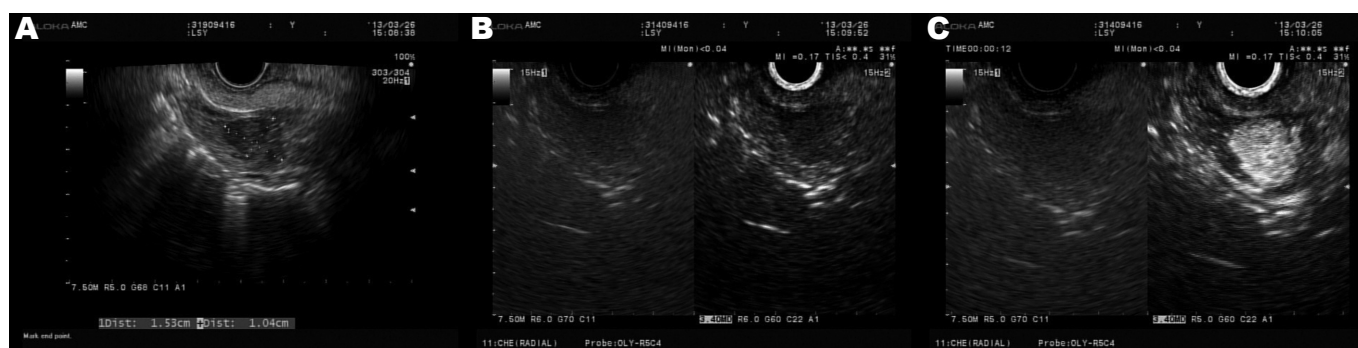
Neuroendocrine tumor. A: Hypoechoic pancreatic mass on conventional endoscopic ultrasonography; B: hypoechoic pancreatic mass on contrast-enhanced harmonic endoscopic ultrasonography (CH)-EUS (pre-contrast); C: homogeneously-enhancing pancreatic mass on CH-EUS (post-contrast)
